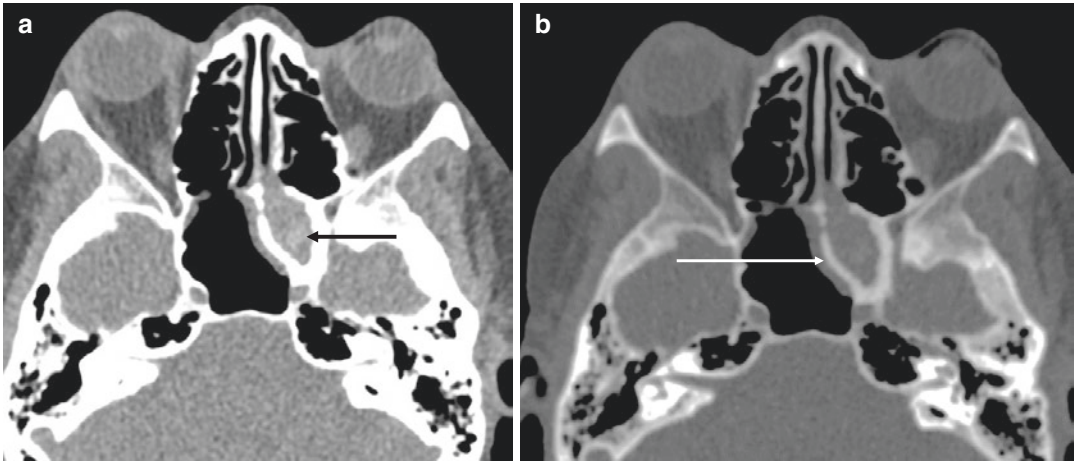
(a and b) Axial CT paranasal sinus study showing a rounded hyperdense focus in the left sphenoid sinus (black arrow). The sinus is opacified with secretions. The
